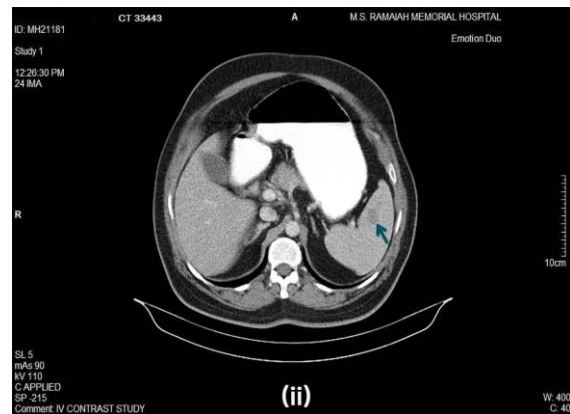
CT scan of the abdomen showing multiple hypodensities in spleen
